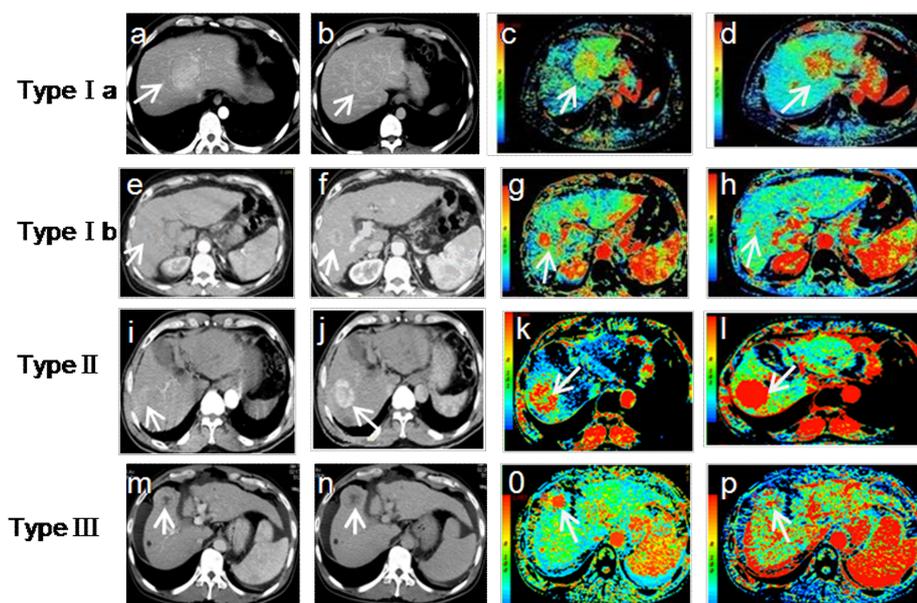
Images of enhanced CT and perfusion CT of tumor edges of different types.
